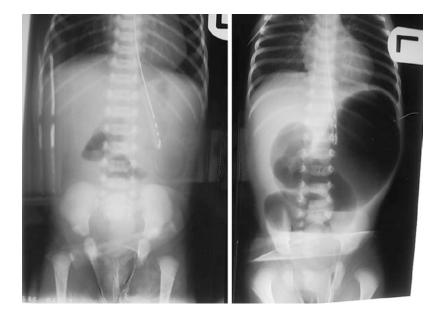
Abdominal radiographs of an infant with jejunal atresia before aspiration via the nasogastric tube and after injection of air as contrast
